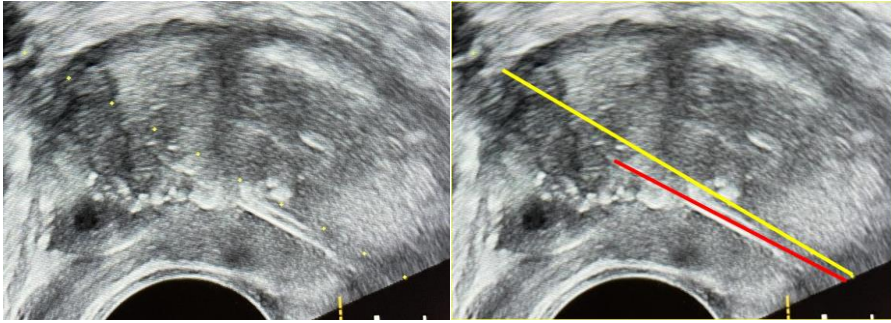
Tru-Cut needle deviation. Ultrasound image of TRbx of a normal size prostate. In the left image is a yellow dotted line guides the user in aiming at cancer suspicious targets, hence the dotted line is the expected needle path. The Tru-Cut needle can be seen deviating below the yellow dots. In the right image the expected needle trajectory has been highlighted by a yellow line and the location of the Tru-Cut needle by a red line. This type of deviation is well known and caused by the wedge design as the closed Tru-Cut needle is forwarded in tissue prior to biopsy. Photo by Andreas Forsvall
